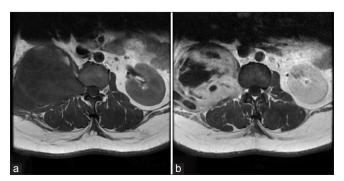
Magnetic resonance imaging examination of the (a) axial T1 and (b) axial T1 with contrast.
